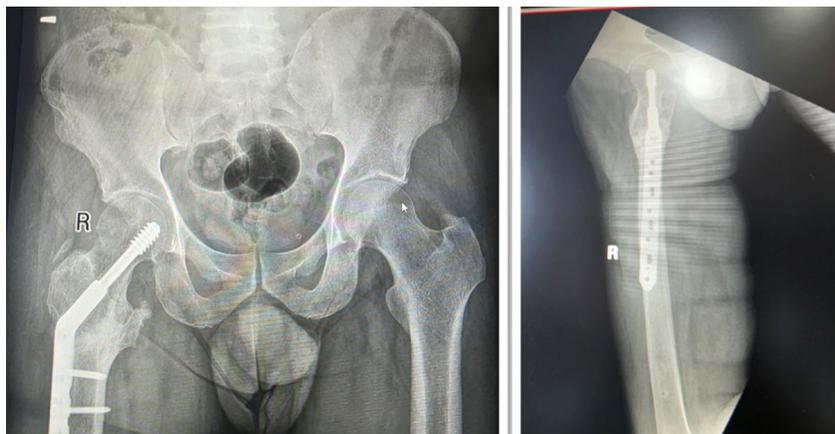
Anteroposterior (AP) and Lateral Plain Radiograph showing placement of lag screw and DHS side plate with long barrel in a case of intertrochanteric femur fracture
